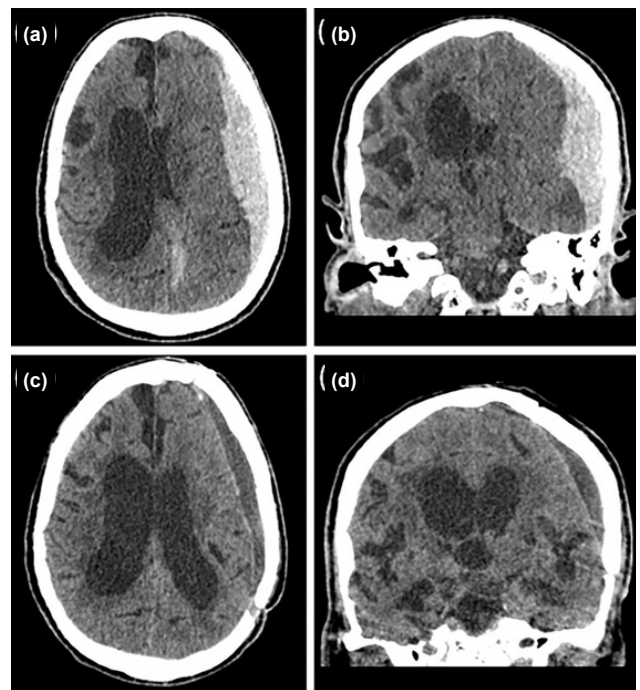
Axial (a) and coronal (b) computed tomography (CT) scans of an 80-year-old man on anticoagulant therapy for coronary artery disease, with an international normalized ratio (INR) within the normal range, who developed confusion after a same-level fall at home. The scans show a left temporoparietal subdural hematoma (SDH). Preoperative neurological examination revealed a Glasgow Coma Scale (GCS) score of 6 and anisocoria in the pupils. The patient underwent urgent surgery, and the SDH was evacuated via open craniotomy. Postoperatively, the patient was monitored under standard conditions in the intensive care unit for the first two days and then transitioned to the inpatient clinic for three days before being discharged home. Axial (c) and coronal (d) CT scans performed four weeks after the traumatic event show minimal subdural effusion and a reduction in brain compression.
